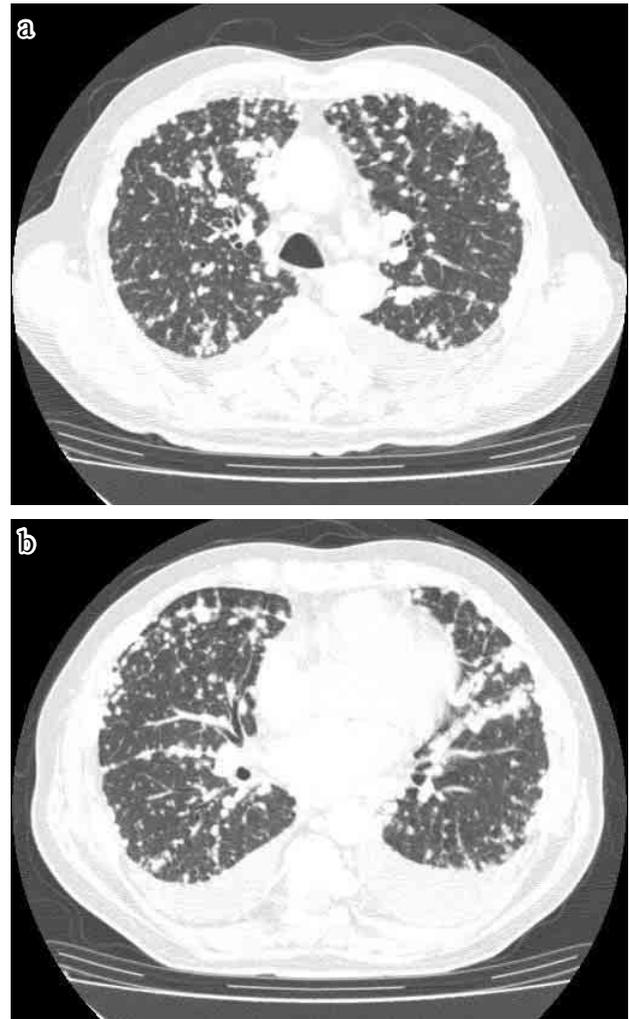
a, b) Chest CT on admission, demonstrating multiple shadows in both lung fields.
